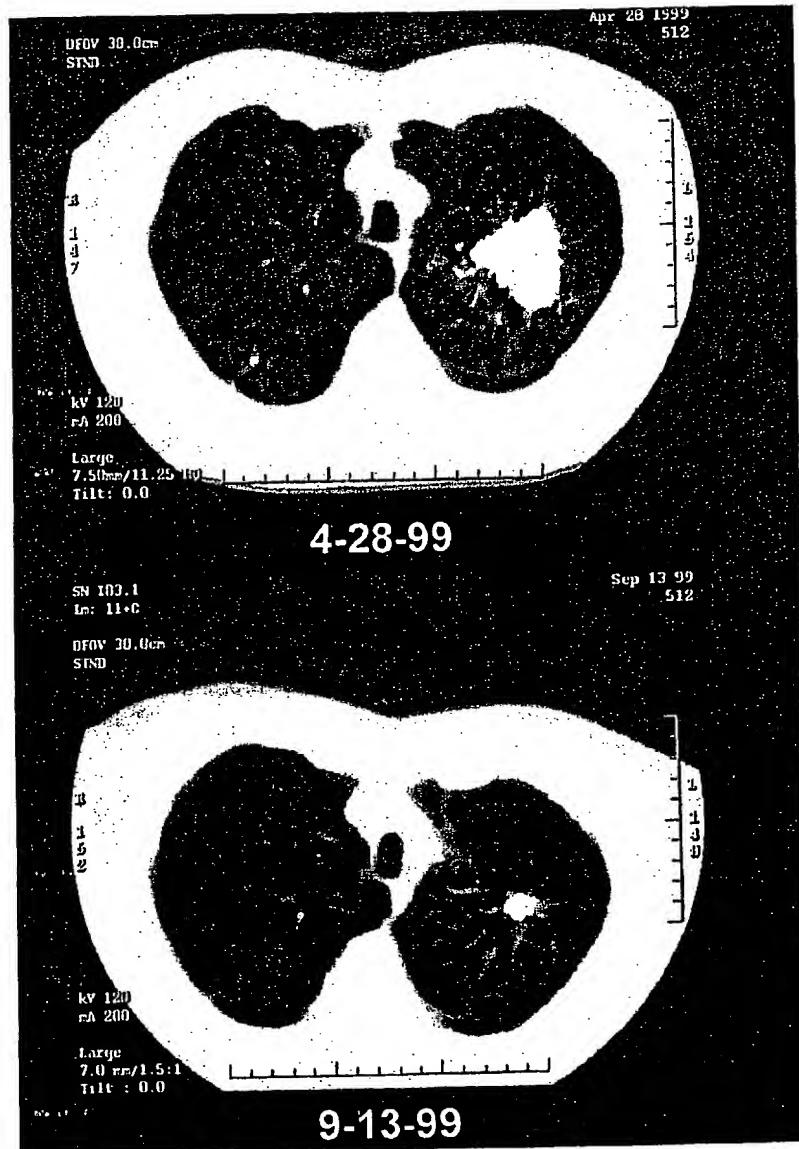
Patient with left upper lobe tumor treated on Phase II trial (Swisher/Roth [28]) with three intratumoral instillations of Ad-p53 and external beam radiation therapy (60 Gy). CT scans are prior to treatment and 3 months after completion of therapy. Core biopsy 3 months after treatment demonstrated no residual cancer and the patient remains disease-free 36 months after treatment.
